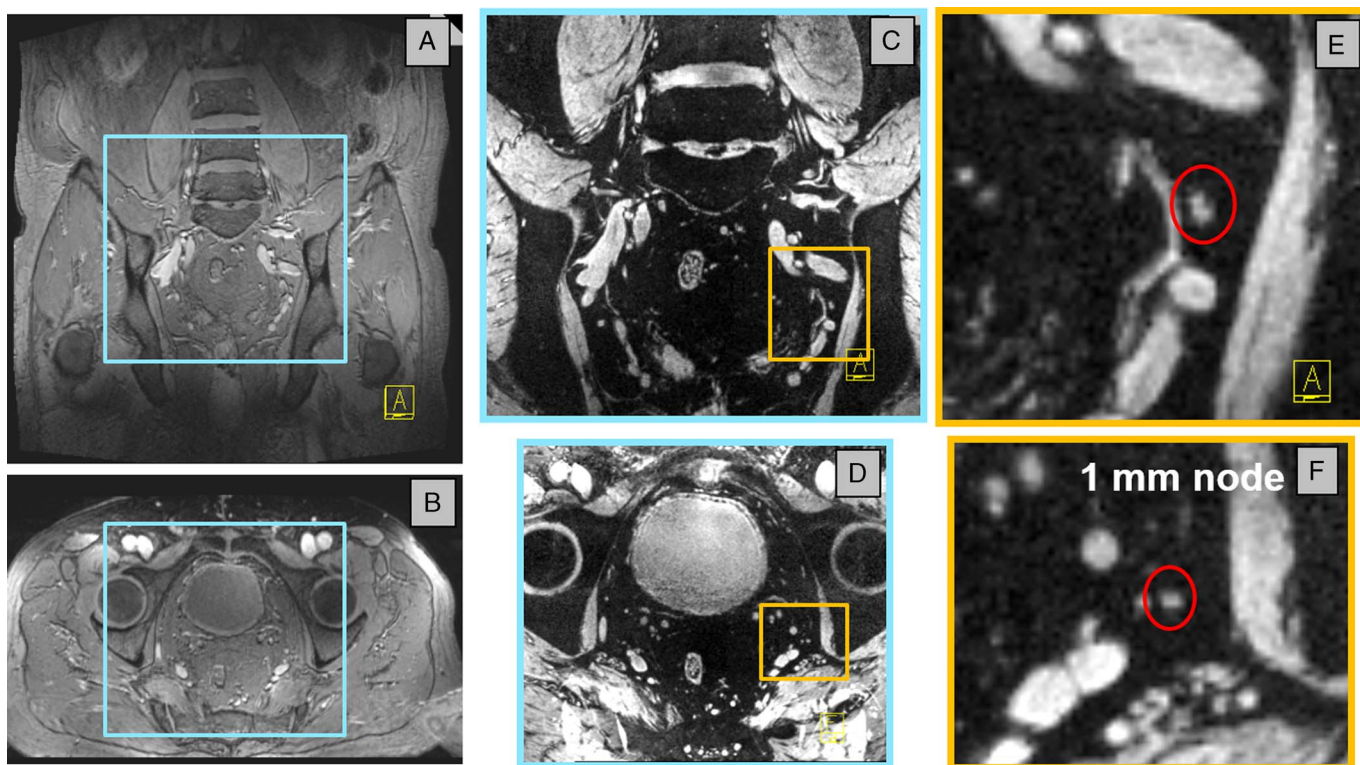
USPIO-enhanced MRI of a 71-year-old patient (94 kg) with metastasized prostate cancer, measured at 7 T, 28 hours after particle administration. Magnetic resonance imaging was performed with an 8-channel transmit/receive coil at 1 echo time with the time interleaved acquisition of mode technique homogenizing image contrast. A coronal (A) and axial (B) overview shows the patients anatomy, whereas the USPIO-enhanced images are iron-sensitive (C and D decreased FOV from blue boxes in A and B). Zooming in on the iron-sensitive MRI reveals a tiny white spherical structure: a 1-mm short axis metastasized lymph node in the red circle (E and F enlargement of yellow boxes in C and D). Parameters: 3D T2*-weighted MRI with echo time 8 milliseconds, resolution $0.66 \times 0.66 \times 0.66$ mm, acquisition time 10 minutes.
